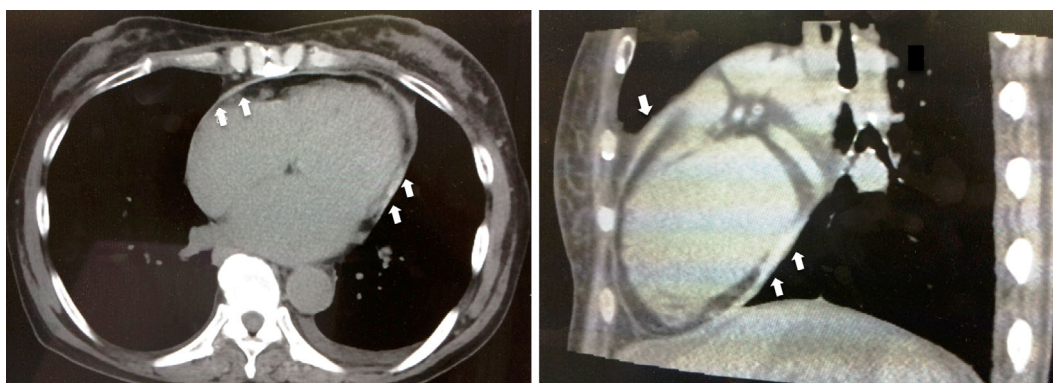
Axial (left) and sagittal (right) views of chest CT showing the thickened pericardium (arrow).
